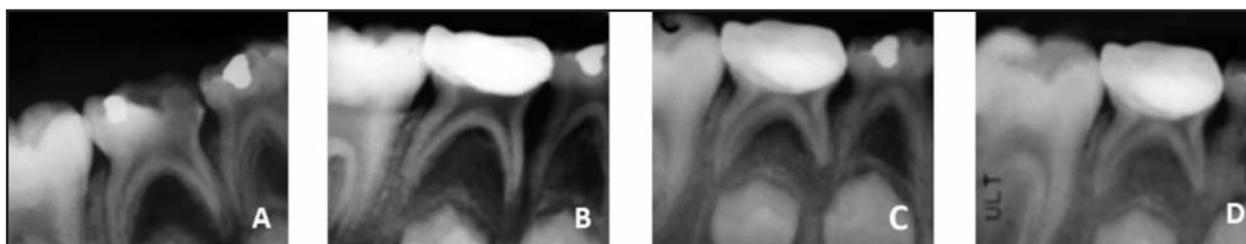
Successful LSTR 3Mix-MP in a lower right second molar with carious lesion involving pulp and interradicular radiolucency. A: Initial image. B: X-ray. 6 months postoperative: shows non-progression of furcation lesion. C: X-ray. 12 months postoperative: reduction in interradicular radiolucency area and presence of new bone formation. D: X-ray. 18 months postoperative: complete resolution of bone lesion.
